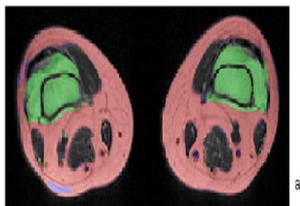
Segmentation of Fat tissue in 4th MRI image
